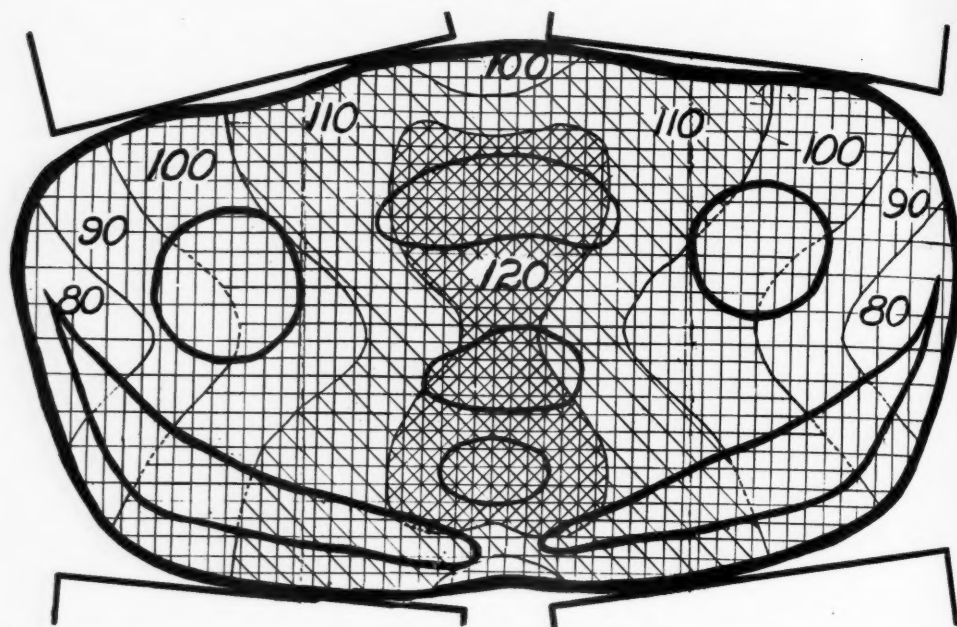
Distribution of radiation in medium-sized female pelvis when irradiated with high voltage X-rays through four portals, as shown: 200 K.V., 0.5 mm. copper and 2.5 mm. aluminum filter, 50 cm. target-skin distance, 15×15 cm. fields, 1 erythema dose for each portal.
